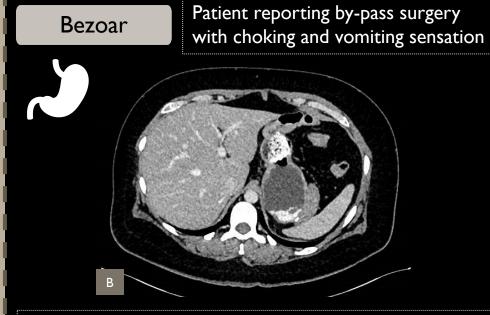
CT with a radiodense oval formation impacted in the gastric enteric anastomosis, associated with distension of the gastric remnant and distal esophagus upstream, suggesting an obstructive / subocclusive process (bezoar)
